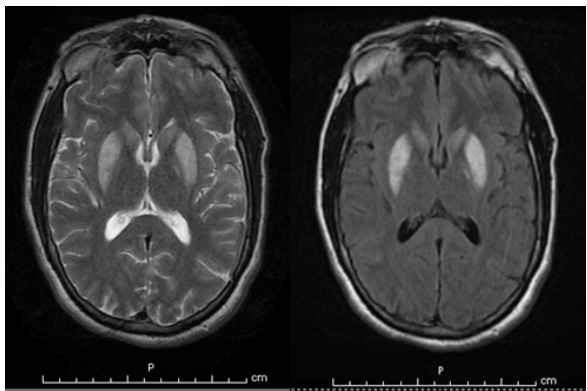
T2-MRI (left) and FLAIR MRI (right) taken approximately 19 days after arrest, showing evolution ischemic damage in bilateral basal ganglia.
